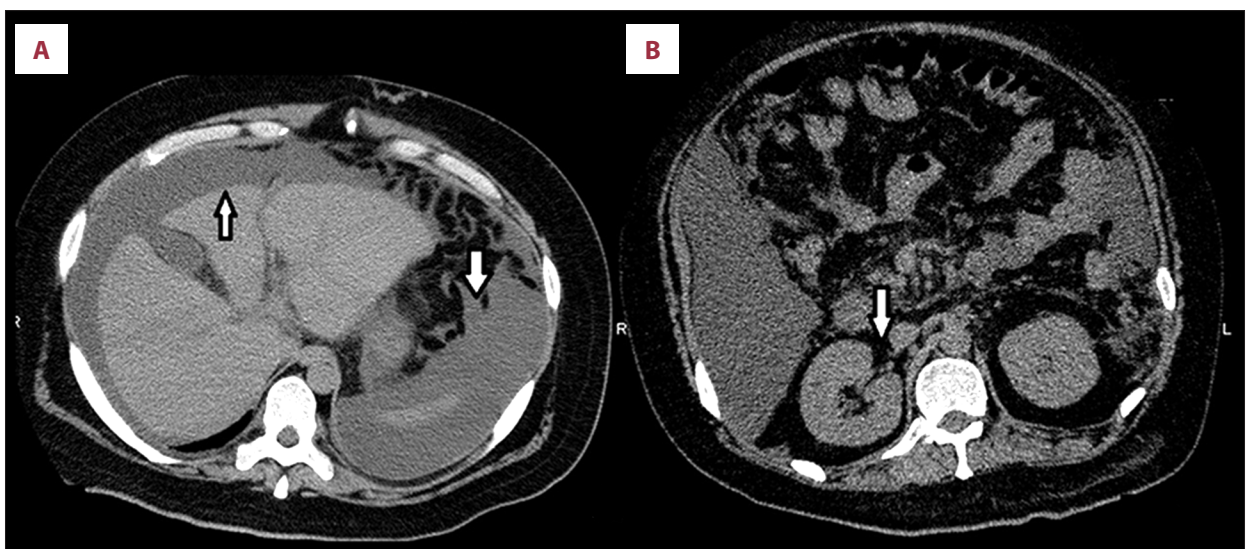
Computed tomography of the abdomen. (A) Massive ascites and obesity was observed (arrow). (B) The pelvic viscera was compressed by the ascites (arrow).
